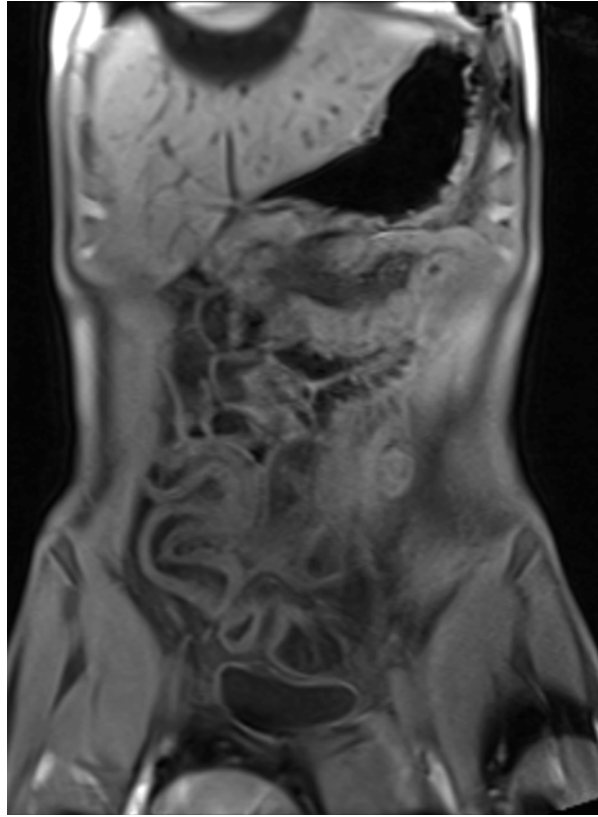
Coronal T1-weighted fat saturated image of a patient with Crohn's terminal ileitis
